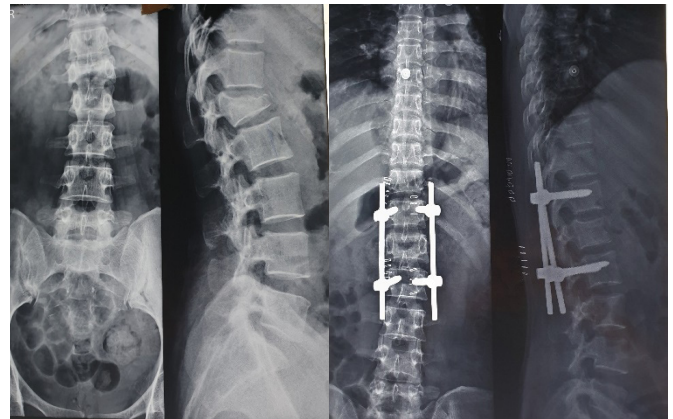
Pre and post op radiograph
